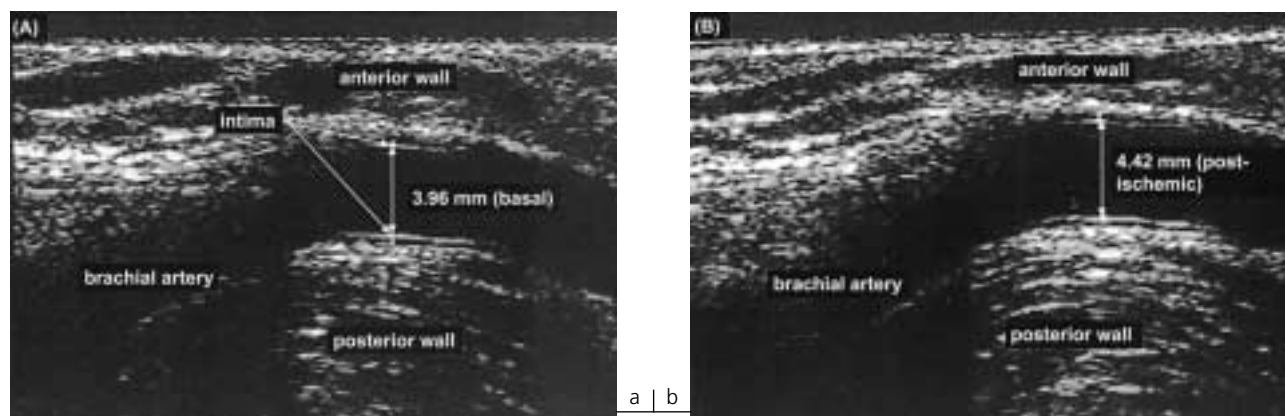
Morphology of the brachial artery measured by ultrasound before and after post-ischemic dilation. Endothelium-dependent vasodilation is evaluated by the difference between the baseline diastolic diameter (A) and the post-ischemic diastolic diameter (B) of the artery (expressed as a percentage).
